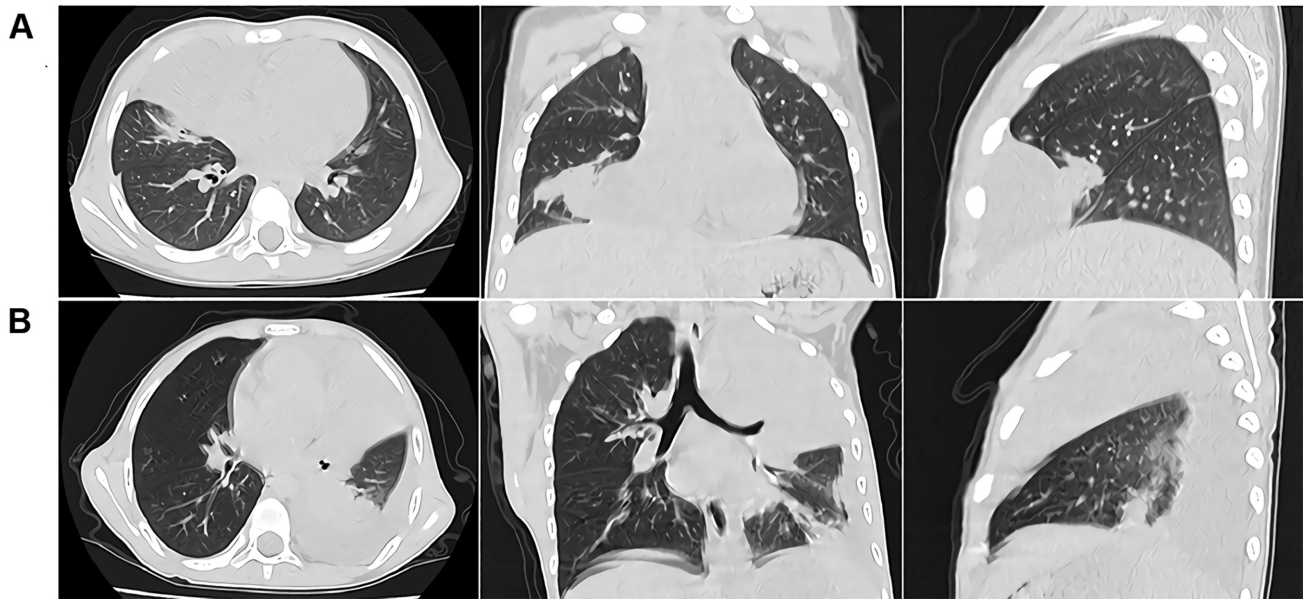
Imaging features of lung injury associated with MPP in children. (A) High-resolution CT scan of the chest revealed areas of consolidation in right middle lobe in a 3-year-old child with mild MPP. (B) High-resolution CT scan of the chest revealed areas of airspace consolidation and pleural effusion in left lobes in a 6-year-old child with severe MPP. CT, computed tomography; MPP, *Mycoplasma pneumoniae* pneumonia.
